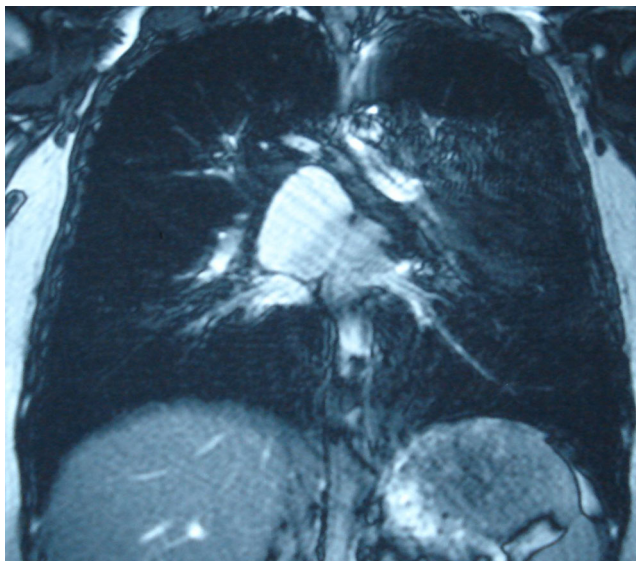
An MRI image showing a bronchogenic cyst in the posterior mediastinum with high-signal-intensity contents
